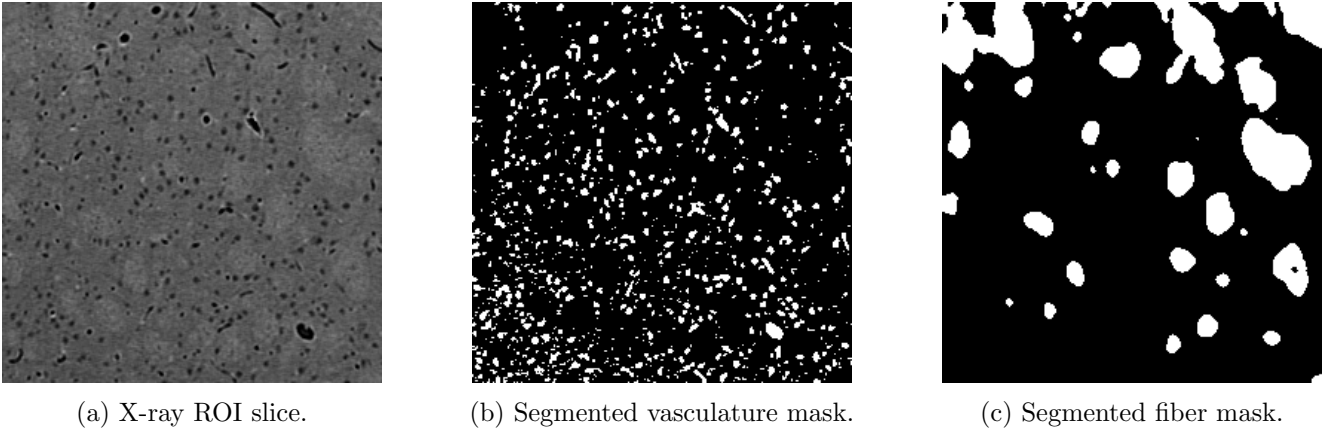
Sample X-ray slice with vasculature and fiber masks.
